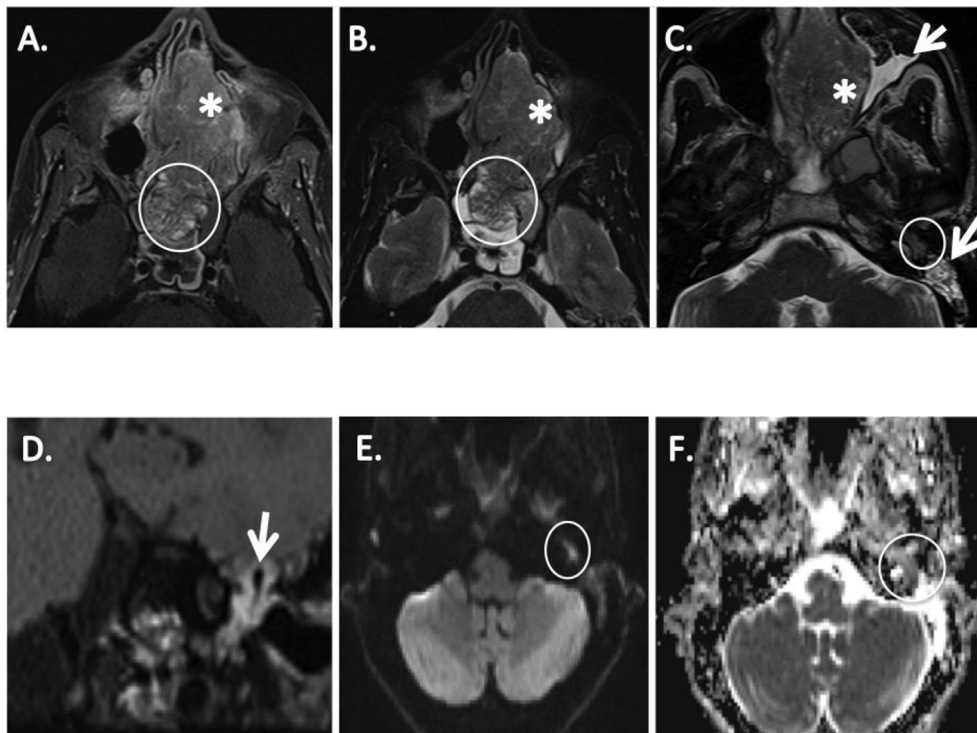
A. Axial T1 MRI with contrast and B. Axial T2 MRI demonstrate a large intranasal mass (asterisk). A portion of the mass at the sphenoid sinuses (circle) demonstrates frond like heterogeneous enhancement with a “mini-brain” appearance characteristic of inverted papilloma. More anteriorly the heterogeneity is lost consistent with pathologic findings of degeneration to high grade dysplasia. C. Axial T2 MRI demonstrating the large intranasal mass (asterisk) and trapped secretions in the left maxillary sinus (short arrow) as well as effusion of the left mastoid (long arrow), inverted papilloma (circle) with a more dark appearance. D. Coronal T1 MRI with contrast enhancing inverted papilloma throughout the middle ear cavity, surrounding the ossicles (tip of arrow). E. DWI shows bright signal (circle) and ADC map (F) show dark signal (circle) indicative of restricted diffusion from tumor cellularity in the middle ear.
